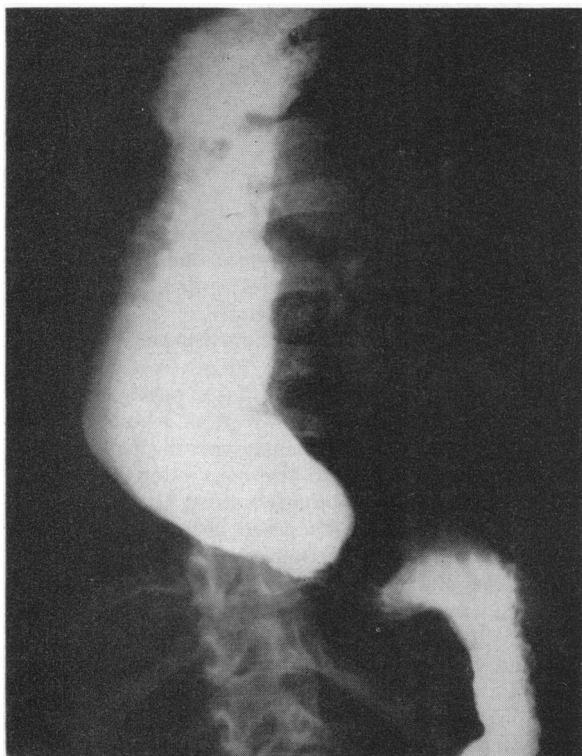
Cardiospasm*. Typical x-ray picture. Esophagus dilated and tortuous. Spastic constriction at the level of the diaphragm. Smooth outline of lower end of esophagus. Only small amount of barium in stomach.
